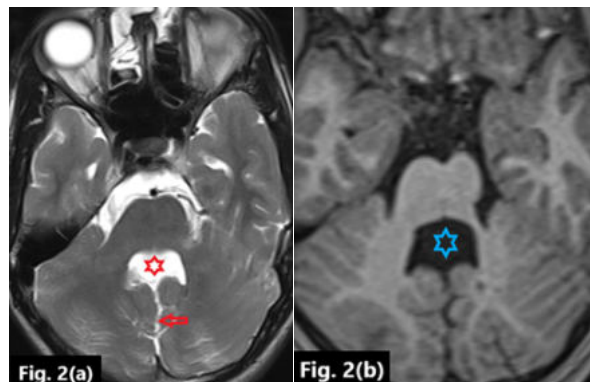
(b). MRI T1 WI axial section showing dilatation of the fourth ventricle with deformed roof and floor giving the shape of a batwing, 'Batwing Sign'.
